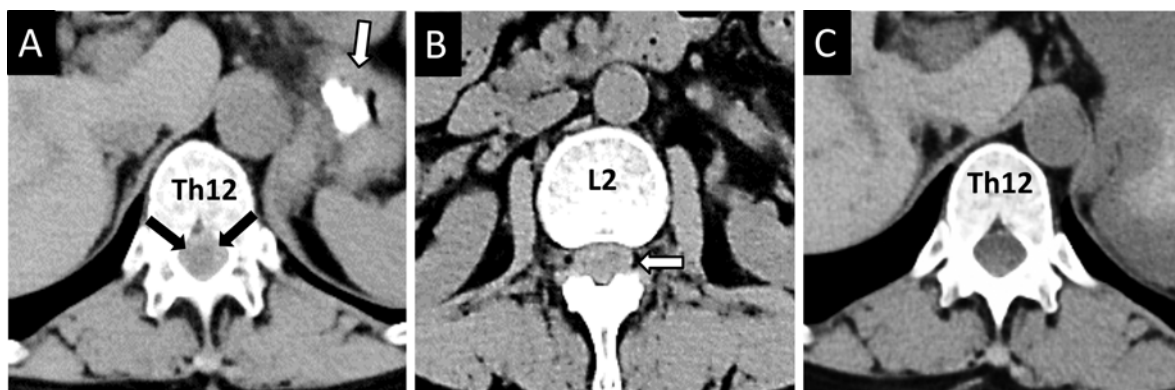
A: Noncontrast CT the day after B-RTO. In the axial image of the 12th thoracic vertebra (Th12) level, the spinal cord was surrounded by high density, which suggests subarachnoid hemorrhage (black arrows). Lipiodol accumulation by EIS was observed in the gastric varices (white arrow). B: Noncontrast CT the day after B-RTO. At the second lumbar vertebra (L2) level, the outline of the dural sac is clearly delineated (white arrow), and the lumen of the dural sac is high density, which suggests subarachnoid hemorrhage. C: Noncontrast CT at ER. In the axial image of the 12th thoracic vertebra (Th12) level, the attenuation within the spinal canal is homogeneous, and it is difficult to distinguish between the spinal cord and cerebrospinal fluid.
